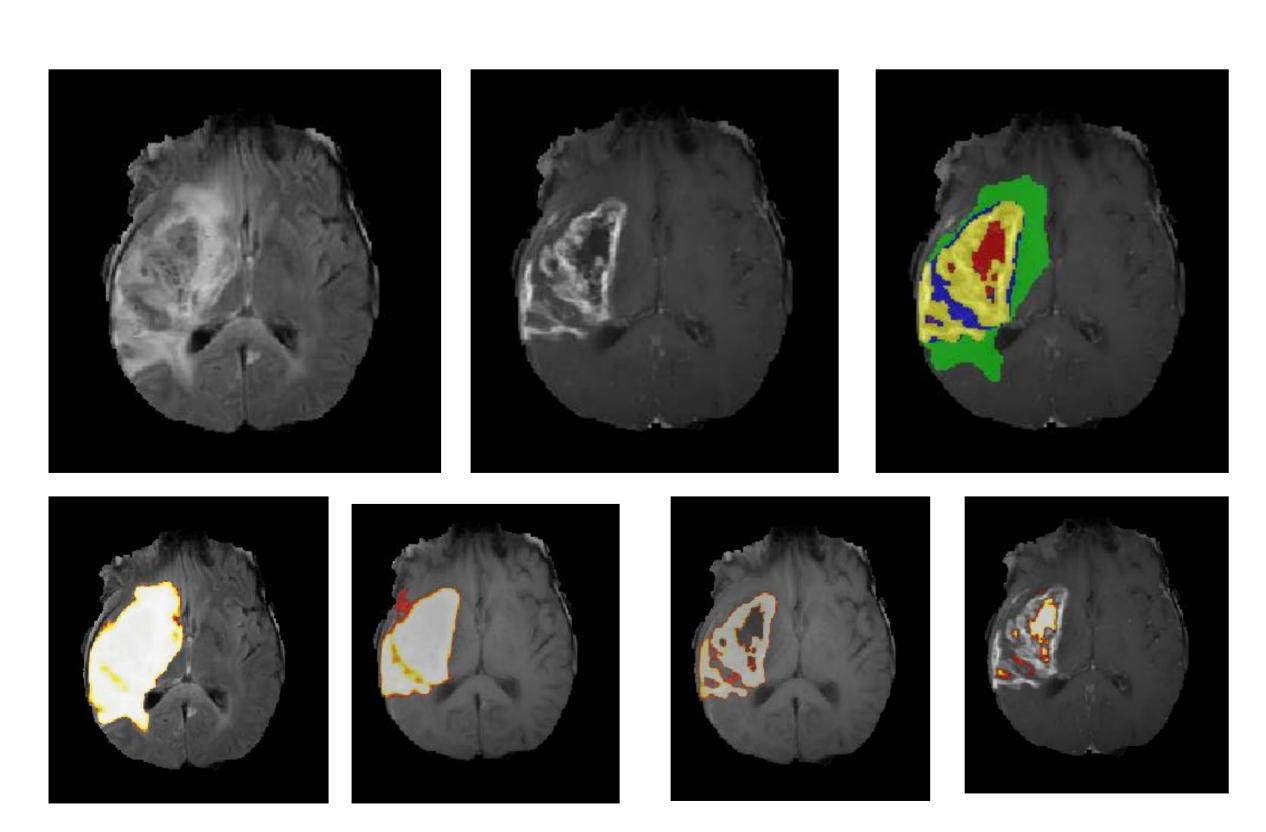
Above: The BRATS nabla net segments brain tumors from FLAIR (left), T1c (middle), T1- and T2- (not shown) weighted imaging, yielding a lesion mask (right) of the tumor compartments.
